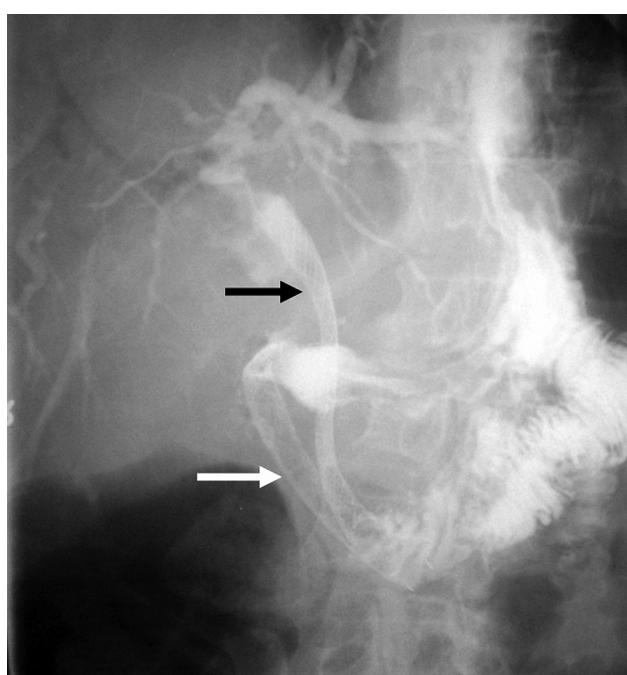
Images from a 77-year-old patient with Oddi carcinoma. Radiograph shows self-expandable duodenal stent (white arrow) and concomitant percutaneous biliary metal stent (black arrow).
